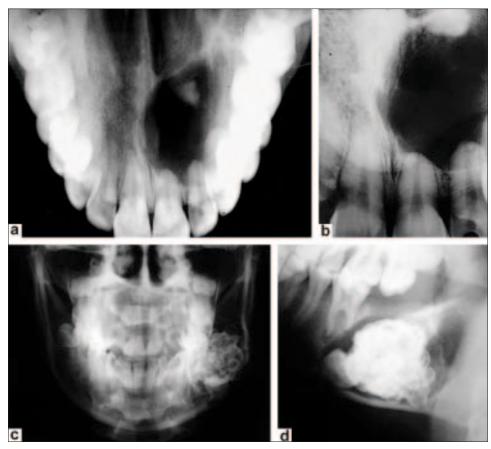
Radiographic examination. First case: (a) occlusal radiograph and (b) periapical radiograph. Second case: (c) posteroanterior and (d) lateral radiograph of the mandible
